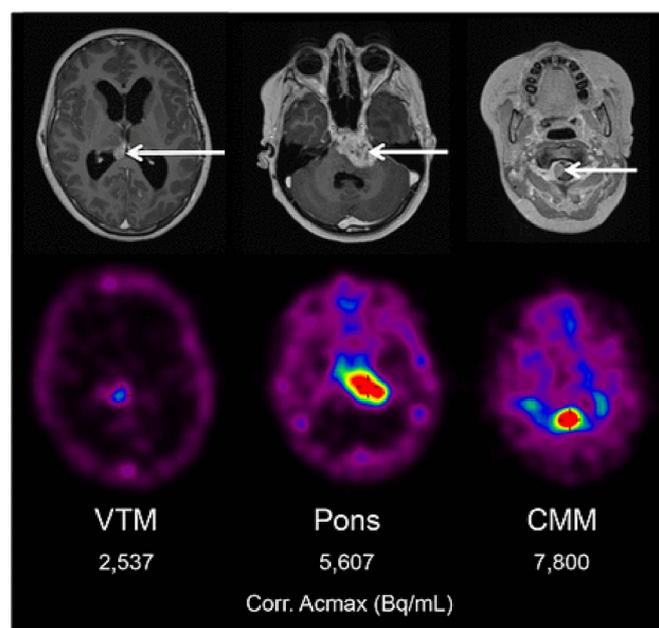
Gadolinium-enhanced T1-weighted MR images obtained 8 days before death (top row), and corresponding PET slices obtained 4 days before death (145 h after ⁸⁹Zr-bevacizumab injection) (bottom row), showing primary pontine tumor and metastases in the right ventricular trigone (VTM) and cervicomedullary junction (CMM). Arrows represent areas of disease. Corr. Acmax = corrected maximum activity concentration. This research was originally published in JNM,⁸⁵ © SNMMI, reproduced with permission.
